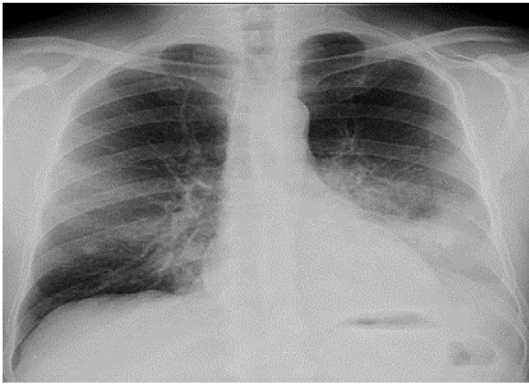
Initial chest radiograph revealed a left lower lobe consolidation suggestive of pneumonia.
